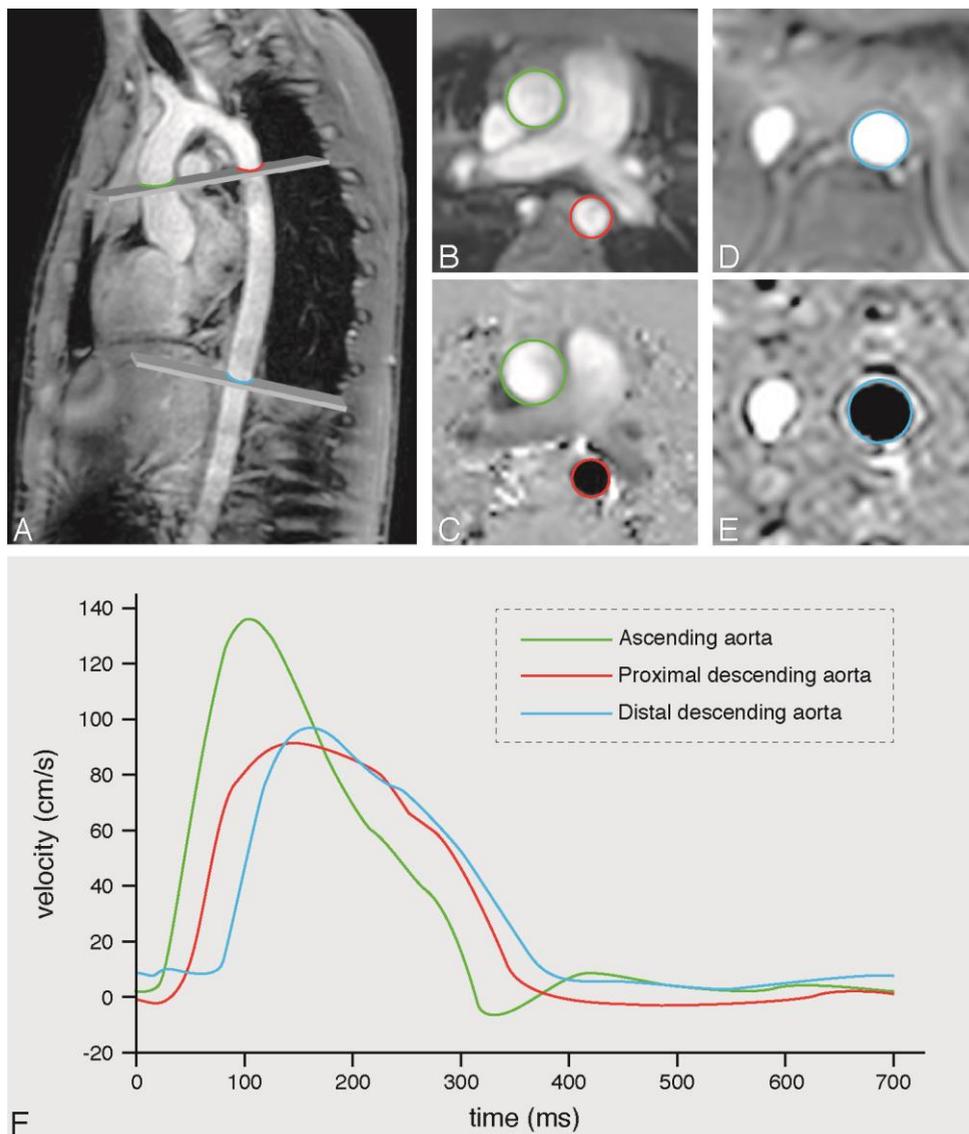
Pulse wave velocity assessment. Sagittal scout of the aorta, indicating the three sites (green, red and blue) for through-plane velocity encoded MRI acquisitions (A). Transverse image of the upper (B) and lower (C) acquisition plane and associated velocity images (D&E), used to create the velocity-time curves (F). PWV is assessed by dividing the segment length (for the proximal aorta from the green to the red site and for the distal aorta from the red to the blue site) by the transit time needed for the pulse wave to propagate between sites, automatically determined by the foot-to-foot method.
